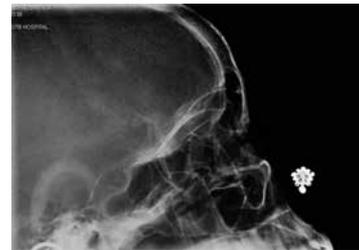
X-Ray orbit-Lateral view
